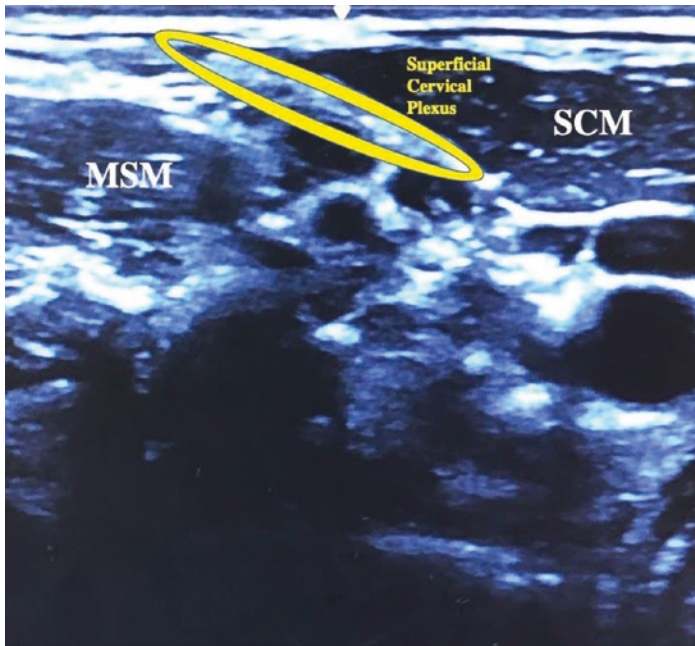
Superficial cervical plexus ultrasound
